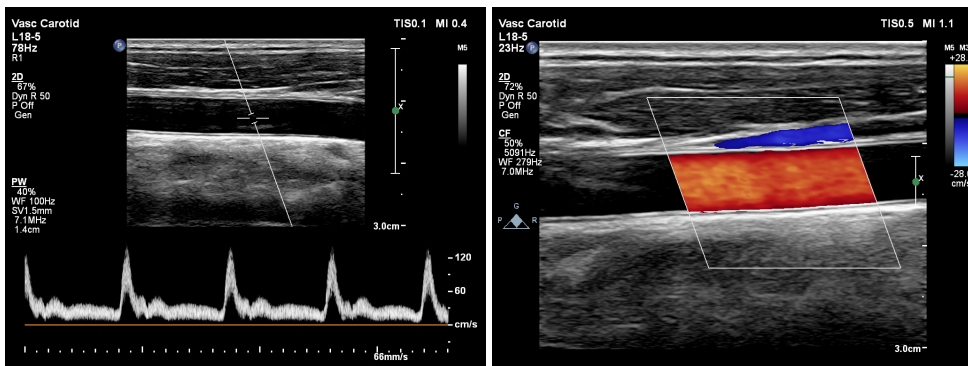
Velocity measurements using ultrasound. Left – pulsed Doppler is used to display all velocity (spectral) components versus time within a user-defined region. Right – color Doppler is used to display the current mean velocity within a larger area using color-coding.
